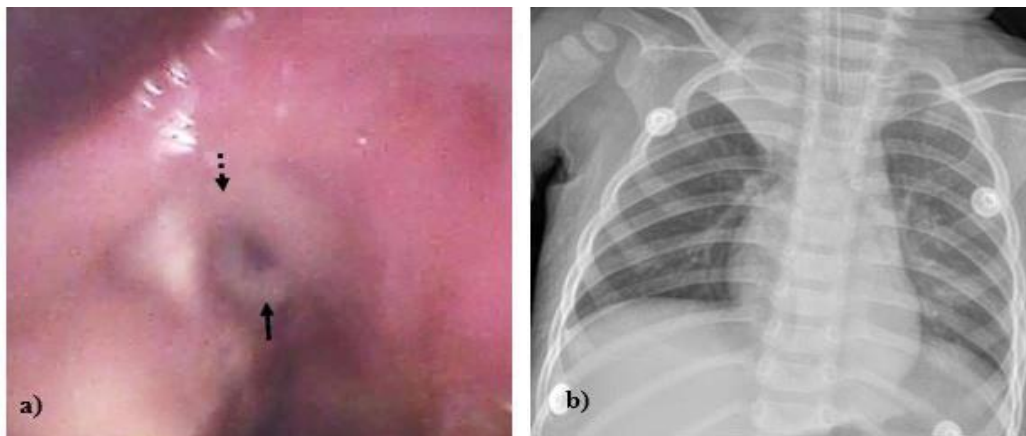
a) Half a piece of nut (black arrow) was stuck in the subglottis area with edematous vocal cord (dotted arrow), b) chest X-ray on day 4 showed atelectasis of right upper lobe of lung
